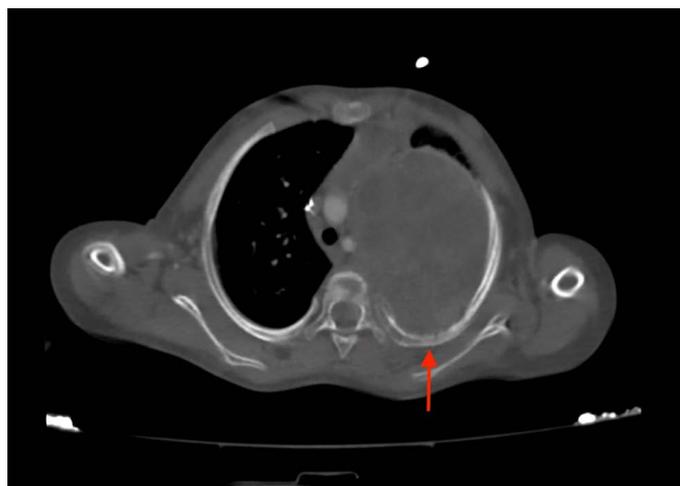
Diagnosis of PES with CT after the first ICA; It changed to ES, which metastasized from the ribs to the lung (solid lesion originating from the posterior of the left 3rd rib, with intact mediastinum and lung intermediate planes, 71X93X89 mm with well-defined borders and necrotic areas).
